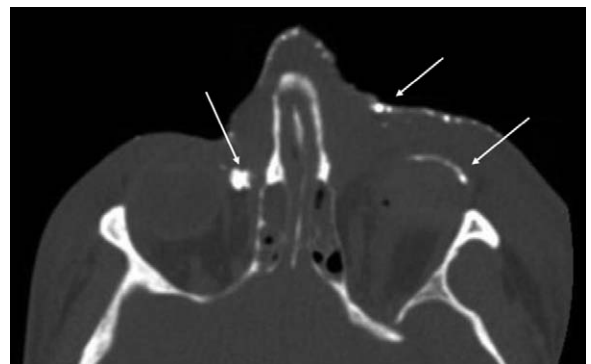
Head CT scan showing white phosphorus particles (white arrows) remaining on the skin and in both eye sockets after three rounds of water decontamination on admission.
